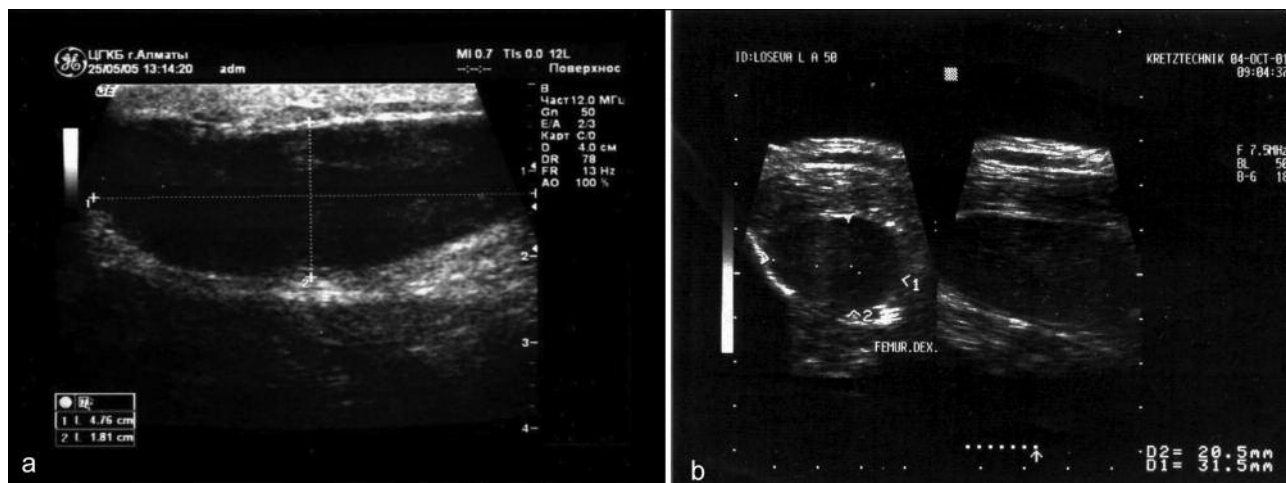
Liquid hematoma located in the subcutaneous fat (a); sonogram of deep intramuscular hematoma (b)
